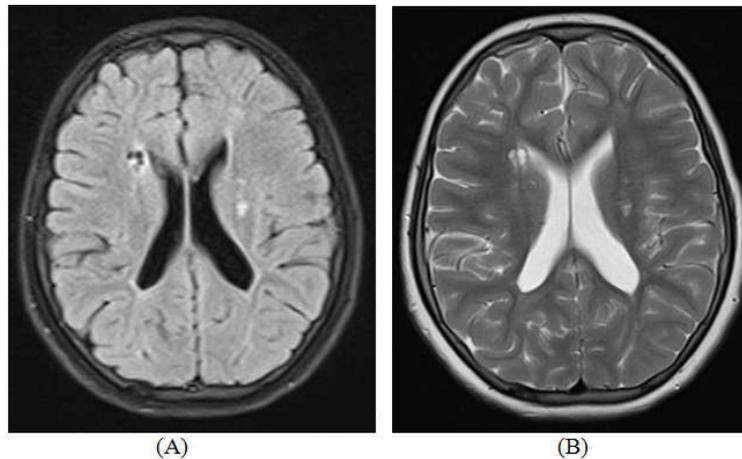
Periventricular leucomalacia – classic pattern of hypoxic-ischemic encephalopathy in preterm infants/children (A) FLAIR, axial (B) T2WI, axial
